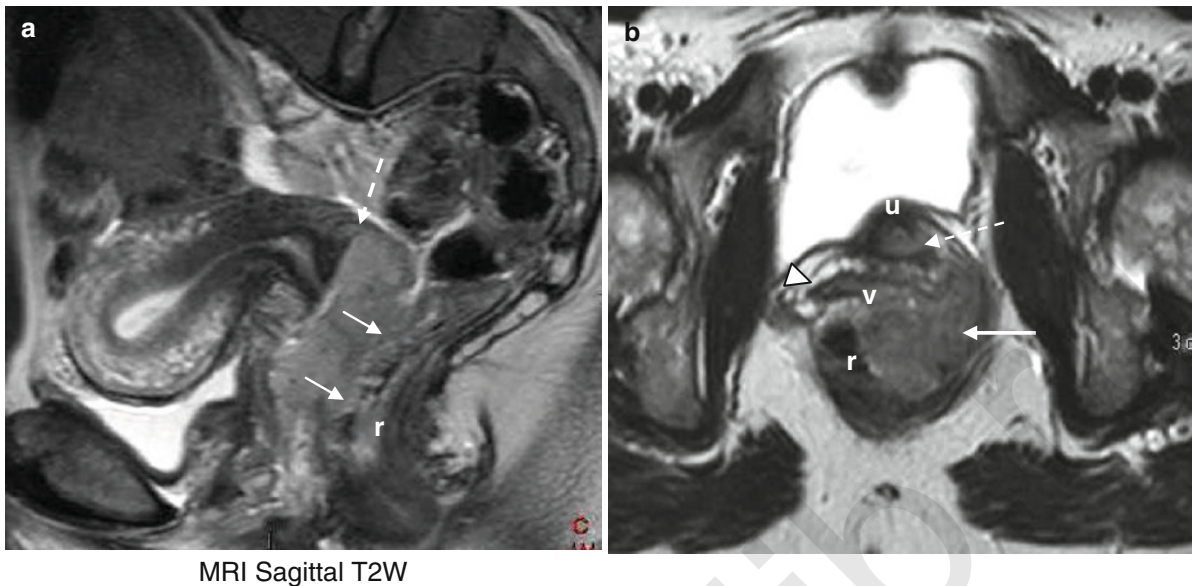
Squamous Vaginal Carcinoma arising in lower vagina 20 years after radiotherapy for cervical carcinoma. MRI Sagittal T2W (a) Tumour (*arrow*) encircling lower vagina and invading urethra (not shown) chronic post-radiotherapy changes to cervix and uterus (*broken arrow*). (b) T2W Axial section lower vagina
